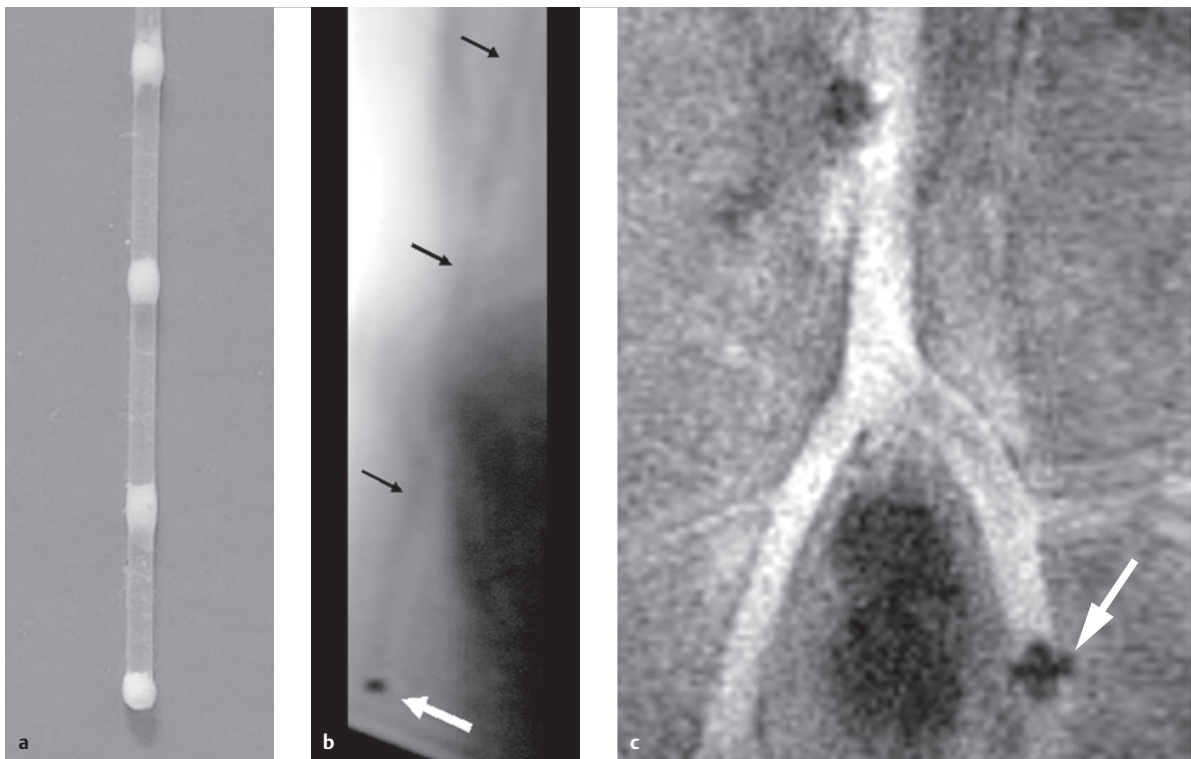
MRI markers. MRI measurements (a, b) demonstrate that the markers (b, white arrow) can be distinguished easily. The instrument, itself, is much more difficult to see in a water bath (b, black arrows).
